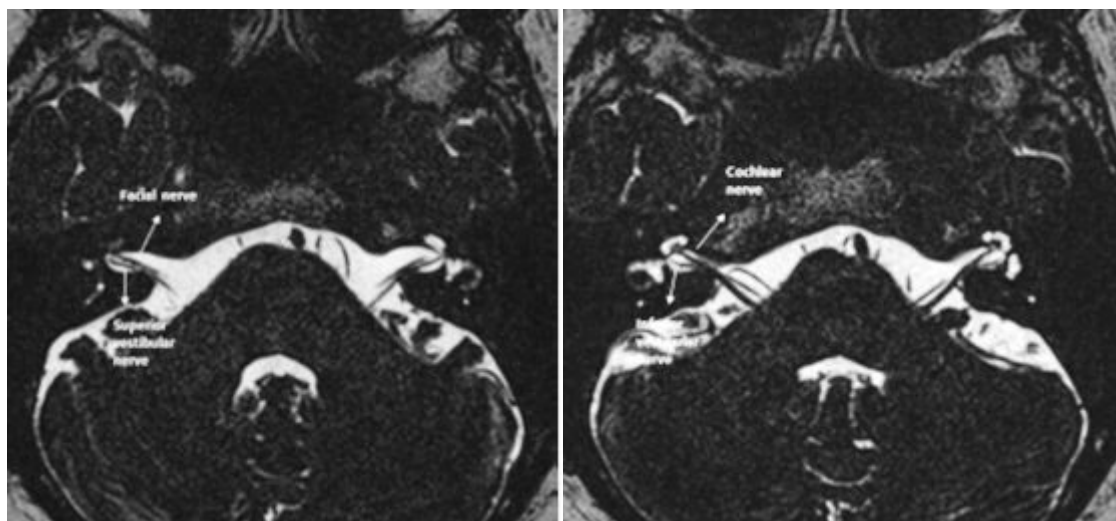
MRI views of Facial and vestibulocochlear nerves within the IAC
